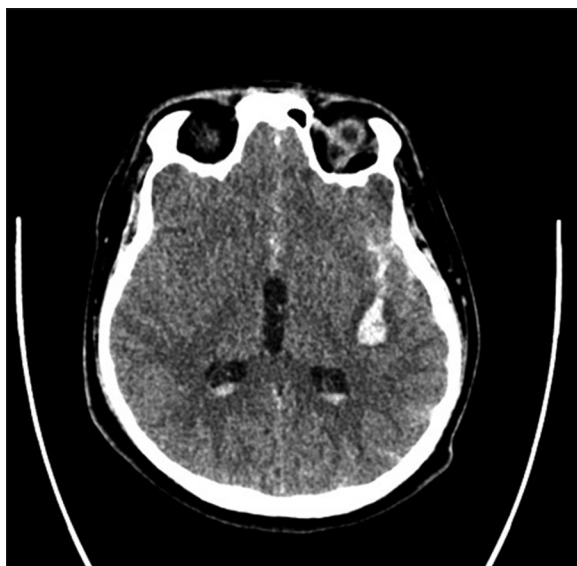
Computed Tomography revealed subarachnoid hemorrhage, intraventricular hemorrhage and hematoma of the left temporal lobe.
